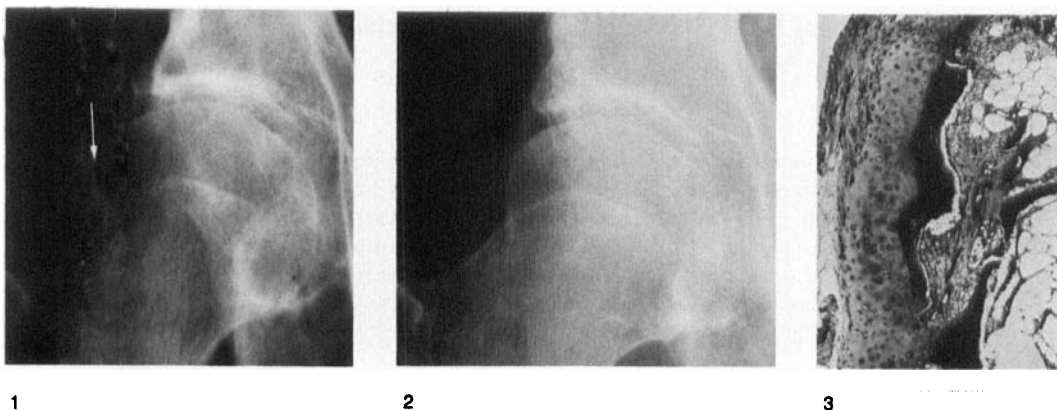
Radiograph of the right hip at presentation showing a tongue-shaped exostosis arising from the posterosuperior aspect of the femoral neck. The arrow indicates the site of the fracture across the pedicle of the exostosis. Apart from some loss of joint space laterally, the joint is well preserved.
